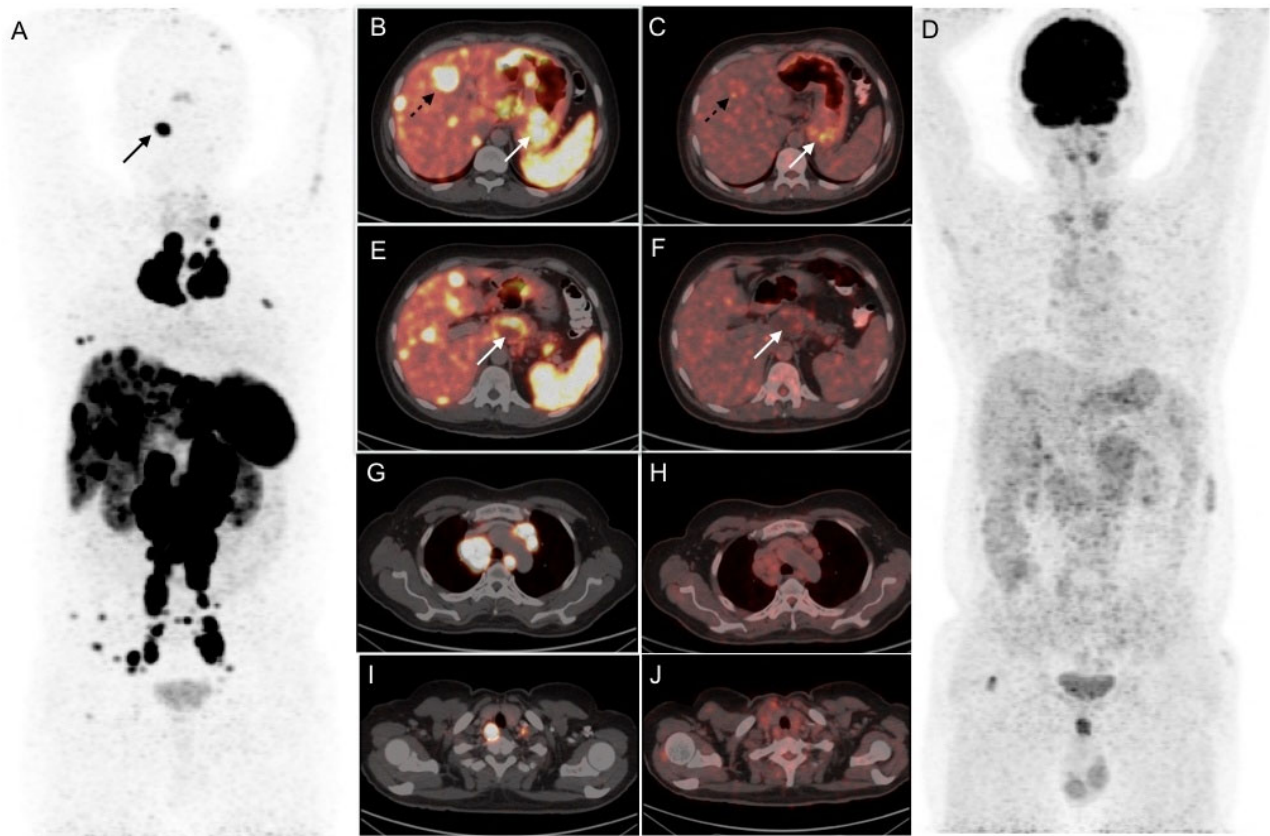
⁶⁸Ga-DOTANOC PET MIP image (A) showing sstr expressing extensive metastatic disease, transaxial fused images showing tracer-avid lesions in the stomach, liver (B; solid and broken arrows), duodenum, cystic lesion in pancreas (E; solid arrow), intramuscular and skeletal deposits (A; solid arrow), multiple enlarged lymph nodes in the abdomen, pelvis, mediastinum (G) and cervical regions (I). ¹⁸F-FDG PET MIP image (D) and corresponding transaxial fused images (C, F, H, J; solid arrows) with low-grade FDG avidity in the above mentioned lesions.
